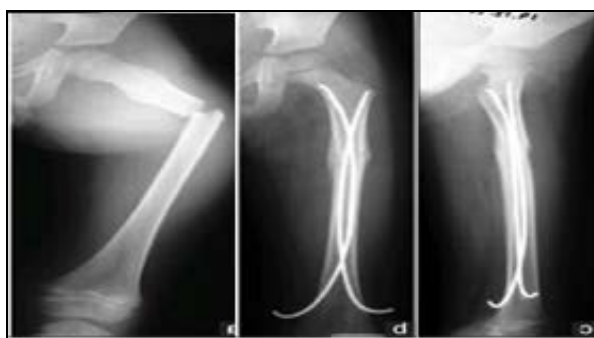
Preoperative radiograph of a 10 year old boy with fracture of the femur, proximal one third of the right femur post-operative follow up radiograph of his thigh (b) AP and lateral view at 12 weeks after surgery showing union and alignment.(c)
